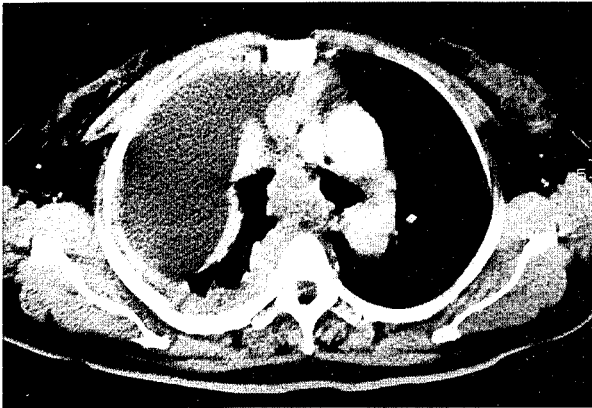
Chest computed tomographic scan showing diffuse enhancing pleural thickness with multiple nodularities, massive right-sided pleural effusion, and collapse of the right lung.
